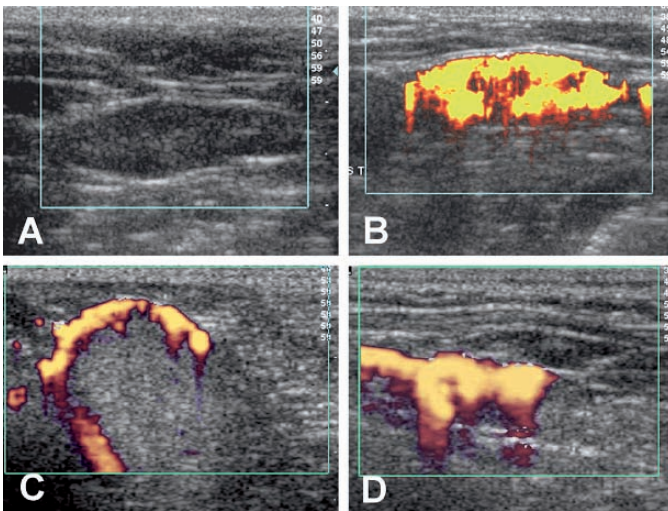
Power Doppler image of a normal canine cervical lymph node before (A) and 30 minutes after (B) subcutaneous injection of Definity (perflutren) into the metacarpus. Parenchymal contrast enhancement is virtually complete in this instance. The central unenhanced region represents the normal lymph node hilus. C Power Doppler image of a popliteal lymph node 15 minutes following injection of a hard-shelled contrast microbubble formulation (1.33 micron mean diameter). Early peripheral uptake corresponds to the region of the subcapsular sinus which receives lymphatic flow from afferent lymphatic channels. D Power Doppler image of a normal cervical lymph node 30 minutes following subcutaneous injection of Definity (perflutren) into the metacarpus. The linear enhancing structure on the *left side* of the image represents an afferent lymphatic channel.
